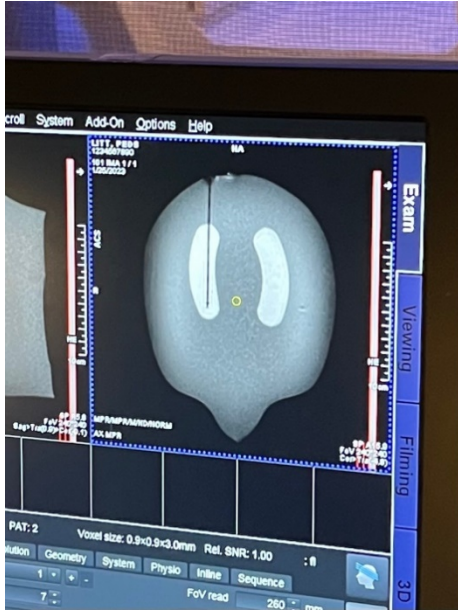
Pre-ablation MRI demonstrating catheter placement (Photo Credit: Joseph Sisk, MD, FAAP)
